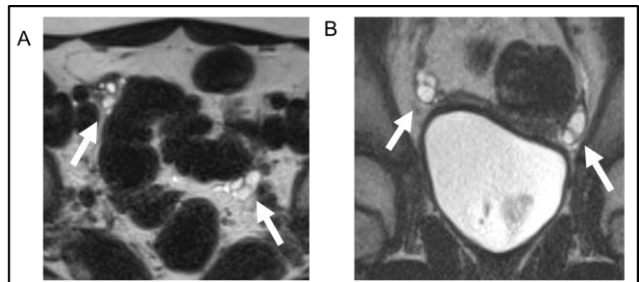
MRI of Premenarchal Ovarian Morphology. Axial (Panel A) and Coronal (Panel B) images of ovarian morphology in premenarchal girls. Arrows denote right and left ovaries.
